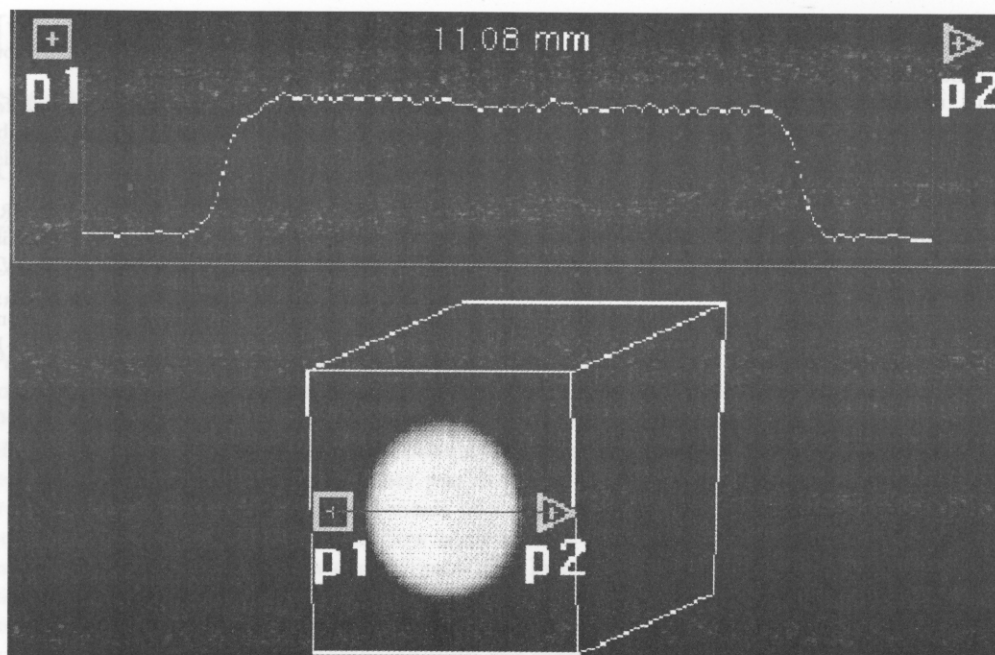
Three-dimensional power Doppler angiogram with a cross-sectional cutting plane provides a transverse view of the flow lumen. The *upper curve* represents the Doppler power plotted across the diameter of the lumen.
